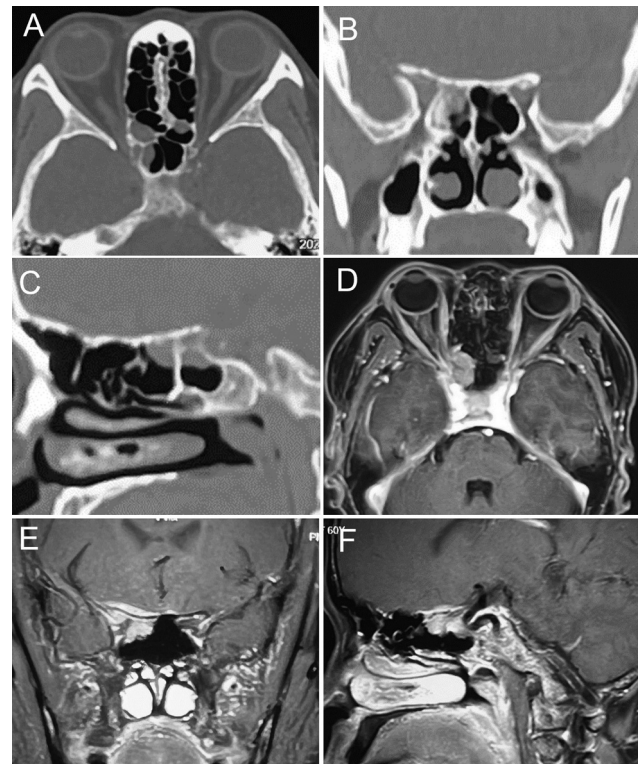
Radiological imaging. CT shows a mass in the right posterior ethmoid and sphenoid sinuses, with no obvious bone destruction (A–C). Enhanced MR shows the mass enhances significantly and extends to the orbital apex and the skull base meninges and the cavernous segment of the internal carotid artery (D–F). CT, computed tomography; MR, magnetic resonance.
